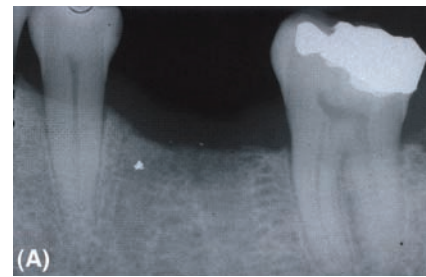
(A) Radiograph of a mandibular molar space indicating adequate room for two implants. (B) Radiograph with transparent overlay of two standard-diameter implants, confirming adequate mesiodistal space. The implants are no longer than the adjacent natural roots and are above the inferior dental canal. (C) Radiograph of two Astra Tech 4-mm-diameter implants used to replace the mandibular first molar. The two implants have been joined together with a gold casting fabricated on two cast design abutments. The abutments are narrower than the implants at the level of the implant head and the shape of the casting facilitates soft tissue contour and plaque control. (D) Occlusal view of the screw-retained casting on the two implants. (E) Lingual clinical mirror view of the completed restoration. A porcelain fused metal crown has been cemented on to the gold substructure. (F) Buccal view of the completed restoration. The space between the implants has been contoured to facilitate oral hygiene with a bottle brush. (G) Occlusal view of the completed cemented crown without access to the abutment screws.
